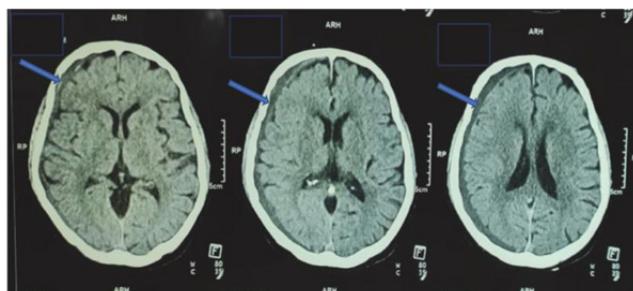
CT scan after four weeks of homoeopathic treatment showing only a rim of hemorrhage without compression of brain parenchyma (arrow demonstrating the hemorrhagic rim).
